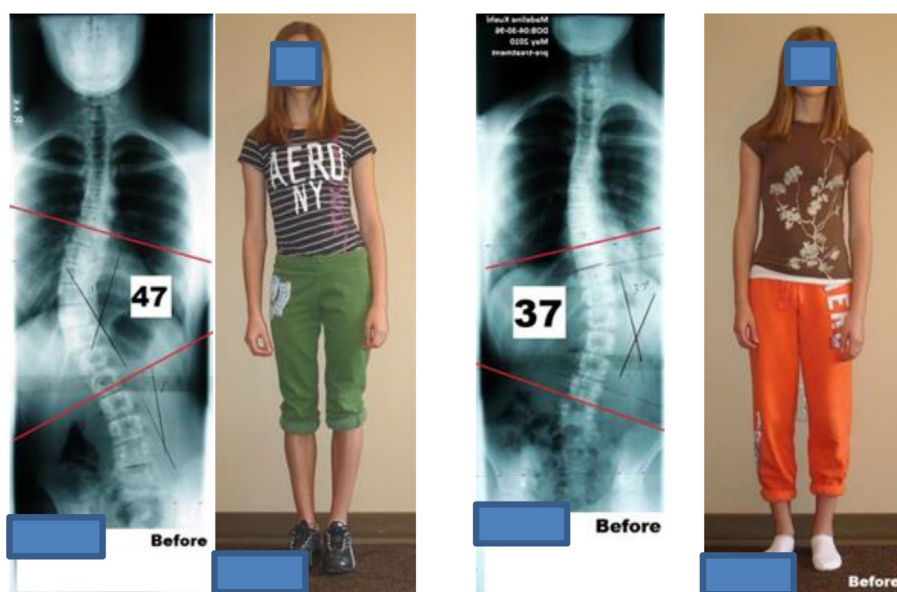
Radiographic Studies Prior to Treatment: (Pt A) –Thoracic 47° Cobb angle T7-L2 (Pt B) –Thoracolumbar 37° Cobb angle T11-L4.
